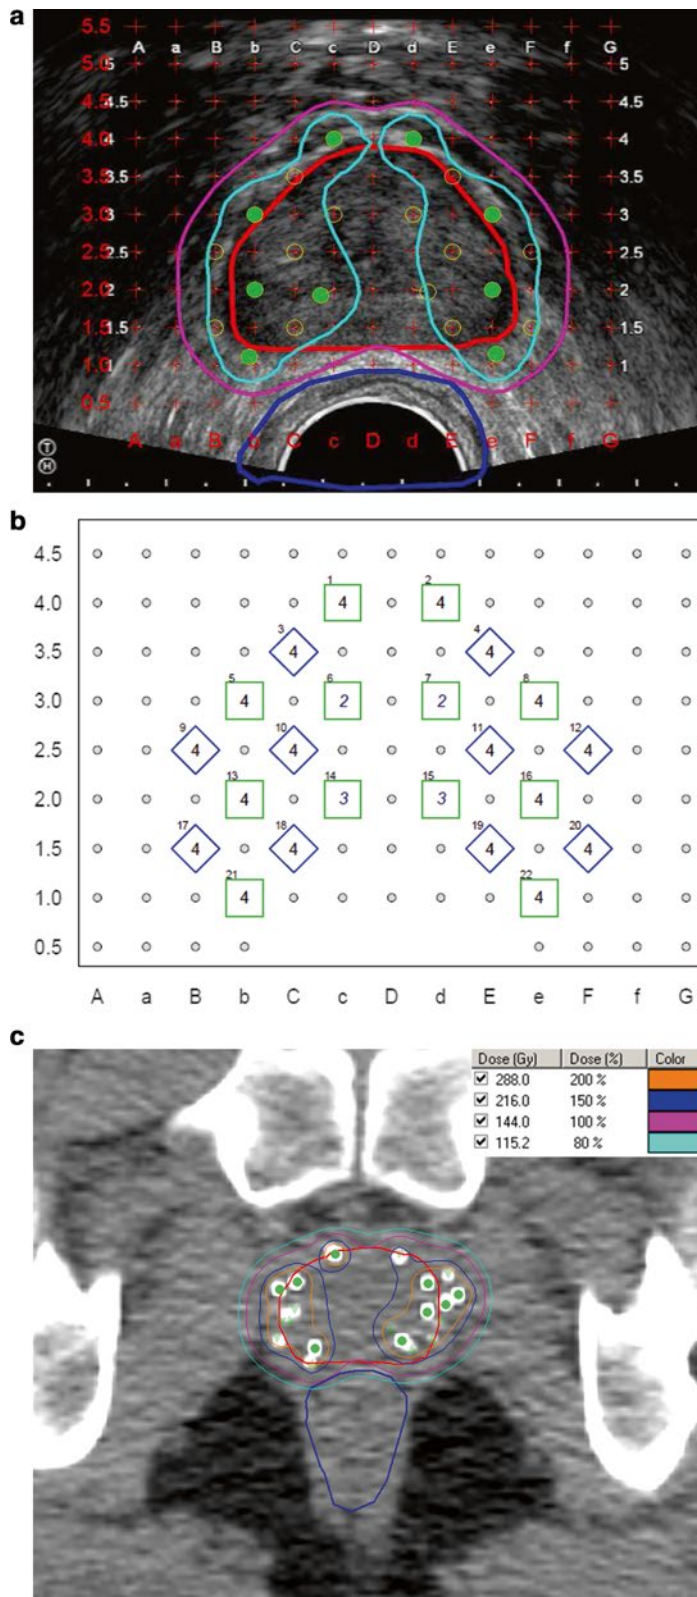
TRUS-guided preplan and the resulting post-plan evaluation by CT. Isodose lines represent varying levels of radiation deposition. (a) TRUS-guided preplan showing the prostate CTV (red) with the 100 % isodose line (purple) and 150 % isodose line (light blue) with seed locations superimposed on the template grid (green).
